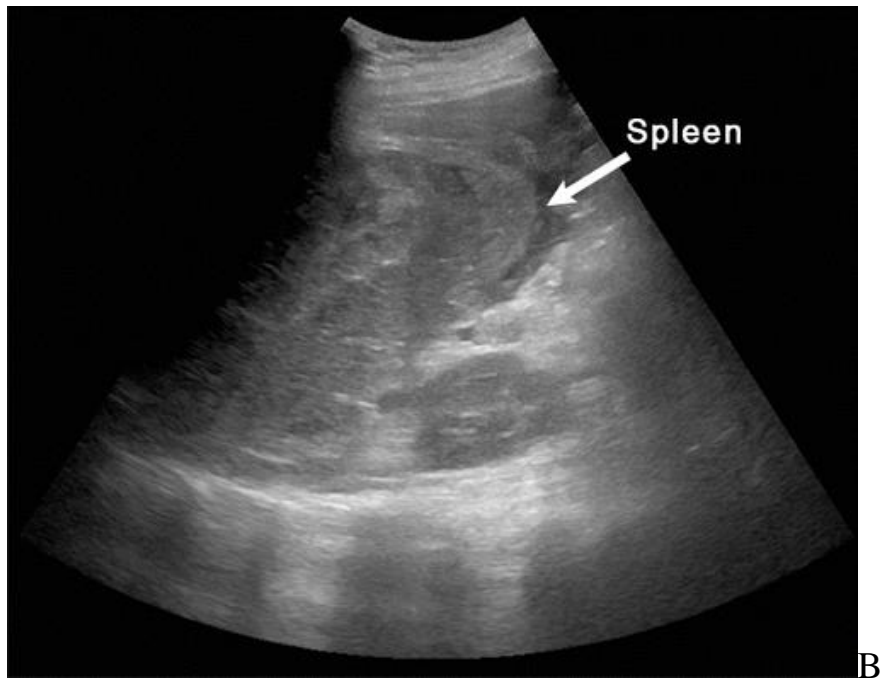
Penetrating abdominal gunshot (bullet) wound. A-Foto of splenic rupture; B - ultrasound view of the splenic rupture, hemoperitoneum (arrow) in B mode; C - Color doppler view of the splenic rupture, hemoperitoneum (arrow).
